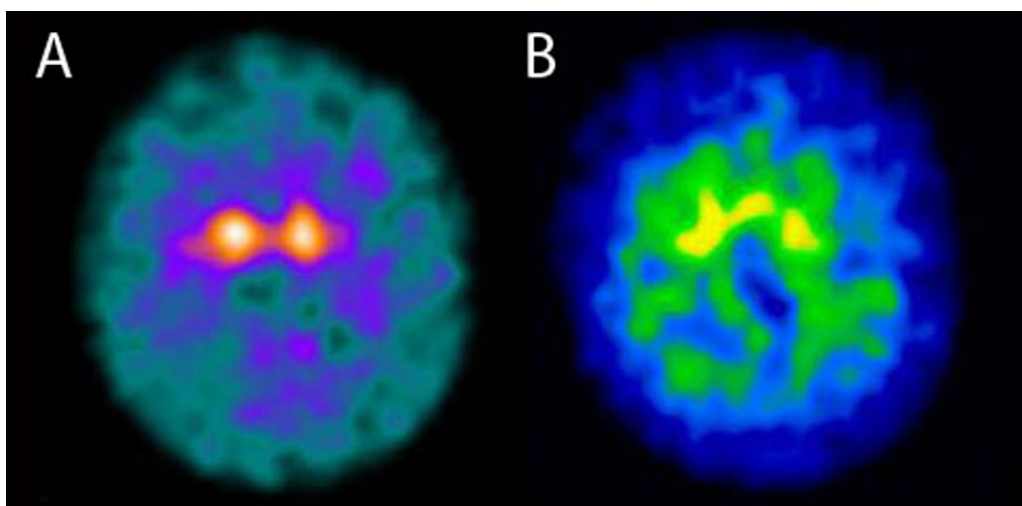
(A) ^{123}I -FP-CIT SPECT reveals a significant bilateral decrease of the putaminal DAT binding. (B) ^{123}I -IBZM SPECT demonstrates severe deficiency of the D2 receptors in the whole striatum on both sides.
